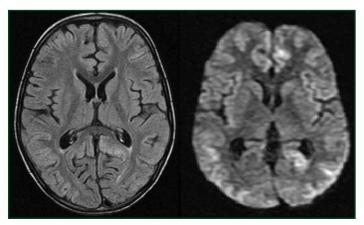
MRI showing gyral swelling with signal intensity alterations in cortical and subcortical region of bilateral parieto-occipital and frontal lobes with no gadolinium enhancement consistent with hypoxic brain damage.
